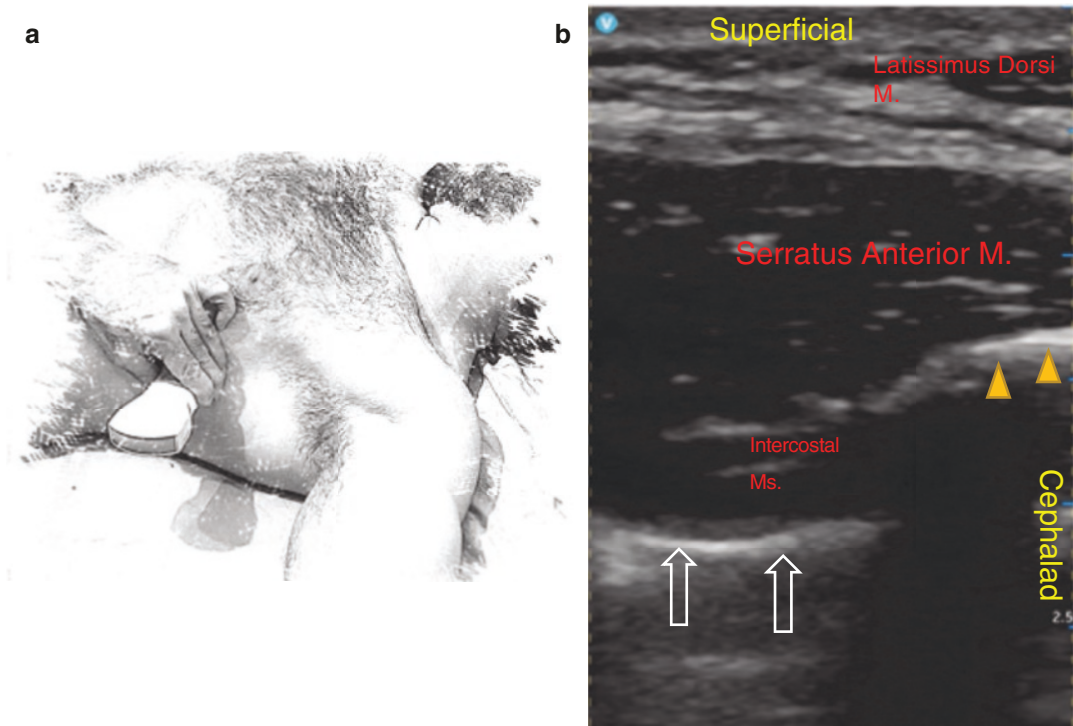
Ultrasound-guided Serratus Anterior Plane (SAP) block. (a) Position of the probe for the SAP block. Blue dot is the location of the needle approach. (b) Ultrasound image of SAP. Interfascial injection is usually performed
